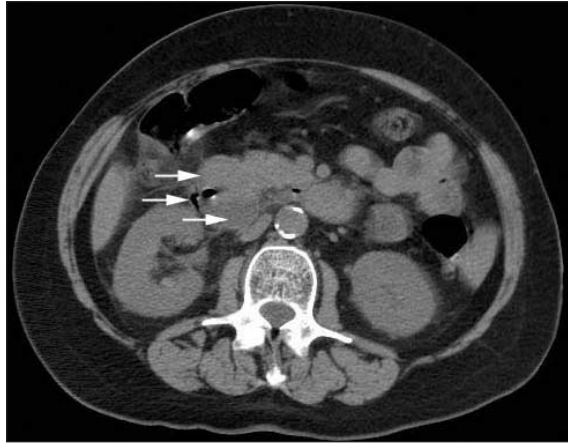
Abdominal CT (without contrast medium) of patient A, showing periduodenal inflammation, thickening of the duodenal wall and the presence of retroperitoneal collections of air and fluid.
